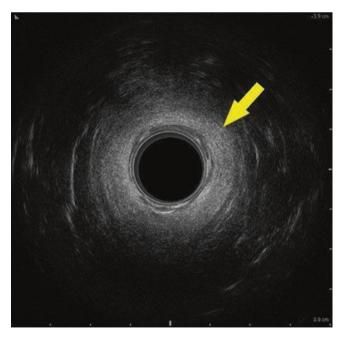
Two-dimensional endoanal ultrasonographic appearance of the lower anal canal, highlighting the external anal sphincter (arrow)
